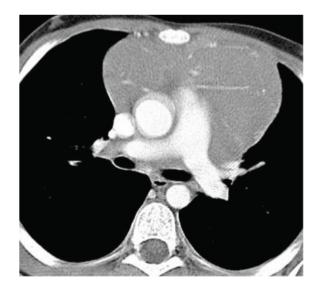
Chest CT showing mediastinal structures
